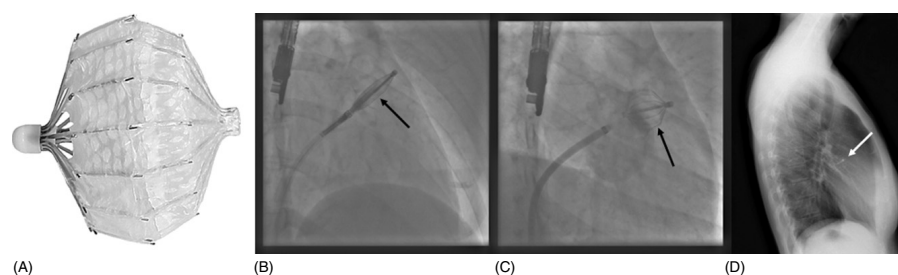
(A) A percutaneous left atrial appendage transcatheter occluder (PLAATO, ev3 Inc., Plymouth, Minn., USA) in the left atrium before its release from the delivery catheter. The implant is constructed of a nitinol frame covered with an occlusive expanded polytetrafluoroethylene membrane. Small anchors along the frame and passing through the occlusive membrane assist with device anchoring. (B) A cineangiographic frame of the PLAATO device before its release into the left atrial appendage. (C) A cineangiographic frame of the PLAATO device after its deployment in the left atrial appendage. (D) The device in-situ as seen on a plain radiograph.
